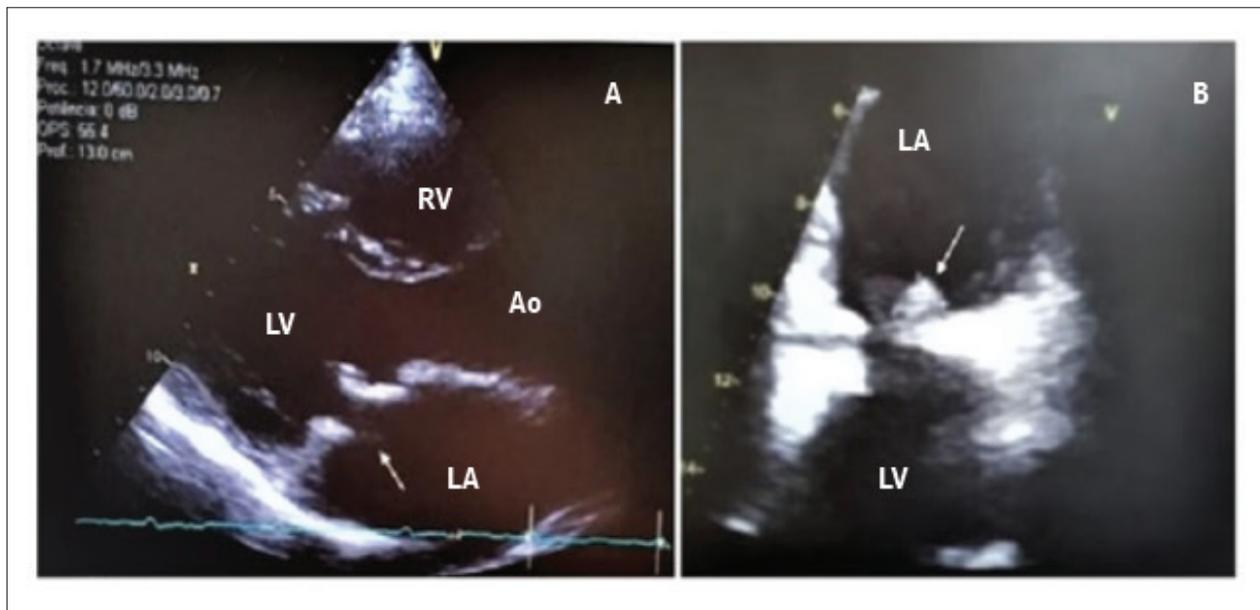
A) 2D TTE in longitudinal parasternal position showing mitral prosthesis with thickened leaflets and pannus aspect. B) 2D TEE at 60° showing an oval shape adhered to the posterior leaflet atrial face. RV: right ventricle; LV: left ventricle; AO: aorta; LA: left atrium.
